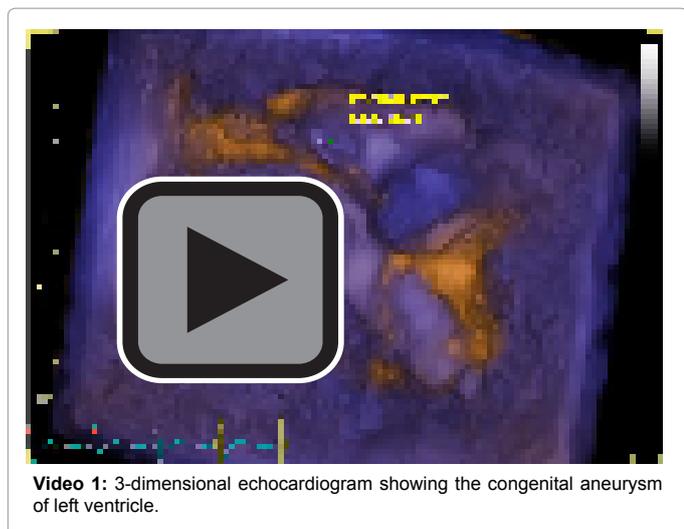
3-dimensional echocardiogram showing the congenital aneurysm of left ventricle.
